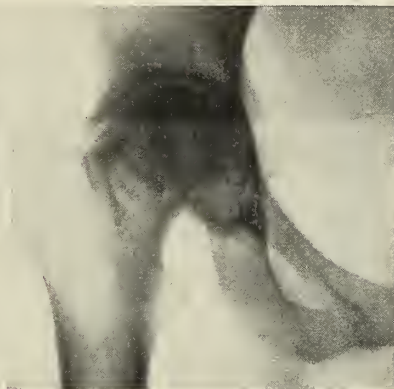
X-ray showing end result following arthroplasty of hip.
